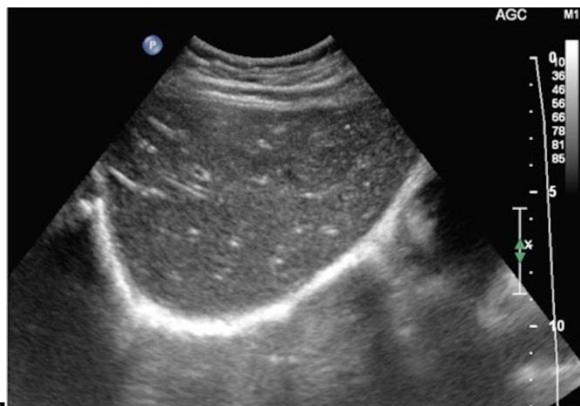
Abdominal ultrasound of liver with acute hepatitis, it shows tiny echogenic foci throughout the liver giving picture of starry night appearance.
